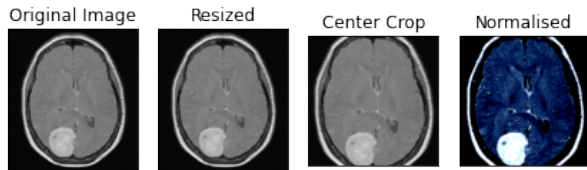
Brain CT-scan pre-processing steps.
